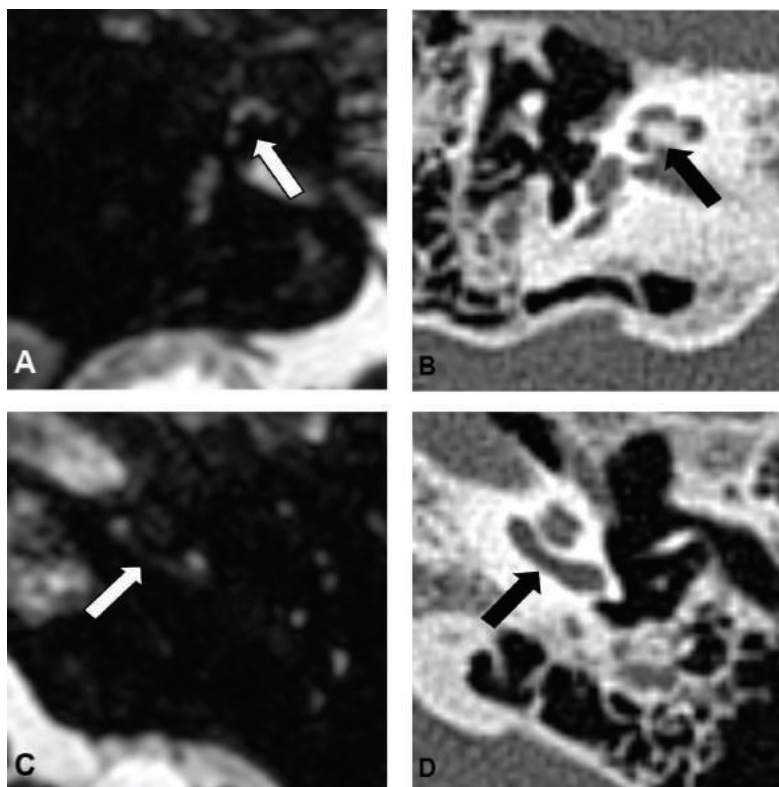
A-D: MRI corresponds better with the surgical findings than CT. Axial 3D heavily T2-weighted MRI and HRCT through the modiolus of the right cochlea (A and B) and through the basal turn of the left cochlea (C and D). T2MRI shows a severe loss of both sides (white arrows, image A+C). Corresponding HRCT shows however extensive calcifications round the modiolus of the right cochlea (black arrow, image B), whereas the basal turn of the left cochlea displays no calcification (black arrow, image D). HRCT can be misleading as this cochlea was full of fibrosis during surgery and only a double array placement was possible (Patient 8).
